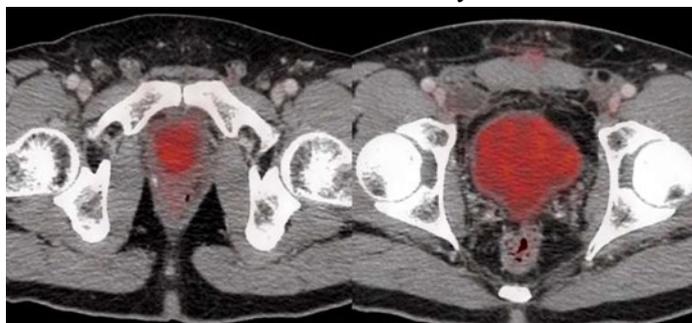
(F) FDG PET/CT Post radical prostatectomy. No FDG avid lesion is seen in prostatic bed or rest of the body.
